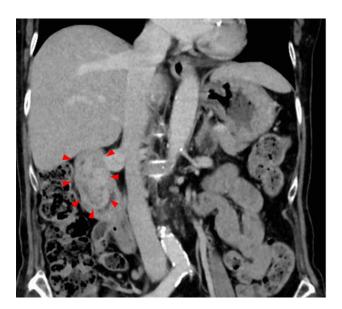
Abdominal contrast-enhanced computed tomography. It revealed a 7 cm protruding lesion (arrowhead) hanging from the bulb to the descending portion of the duodenum. The lesion showed minimal enhancement in the arterial phase and a mosaic-like enhancement pattern in the venous phase.
